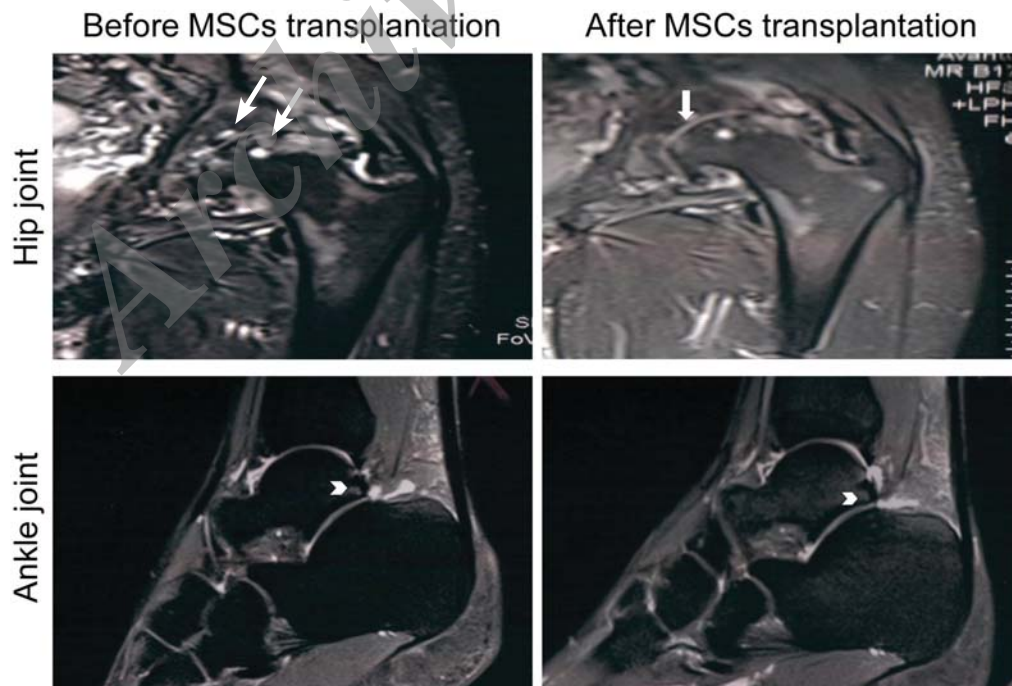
MRI analysis. (A) Sagittal T2 weighted MR image of patient with hip OA shows cartilage surface before MSC transplantation (arrow). (B) Note the predominant increase in cartilage thickness after MSC transplantation (arrow). (C) Sagittal T2 weighted MRI photograph of patient with ankle osteoarthritis (OA). Note the patchy subchondral edema (arrowhead). (D) Arrowhead shows decreased subchondral edema signal at six months after MSC transplantation.
